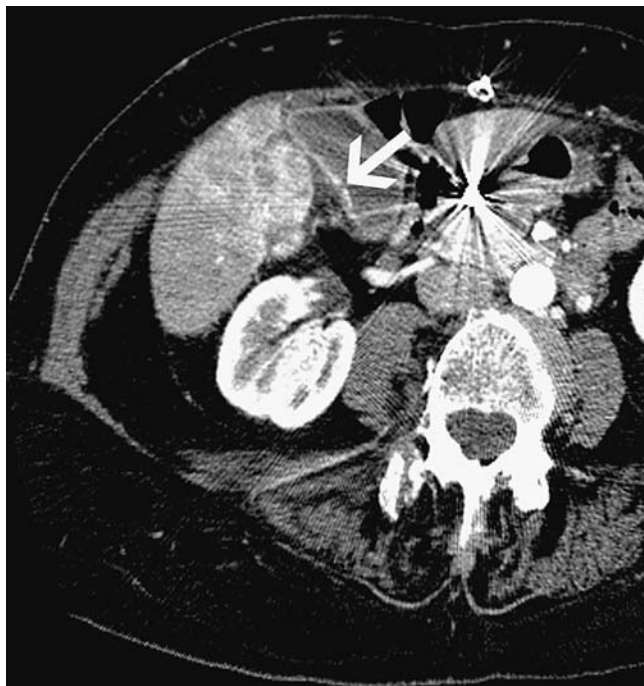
Post-treatment contrast-enhanced CT demonstrates gallbladder wall enhancement with an apparent focal wall disruption (*arrow*). The patient was asymptomatic and was followed clinically.
